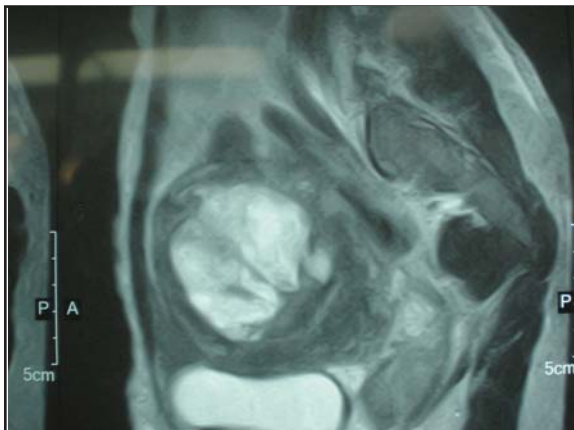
MRI showing placenta after preterm vaginal birth in a P7, 42 years of age.
